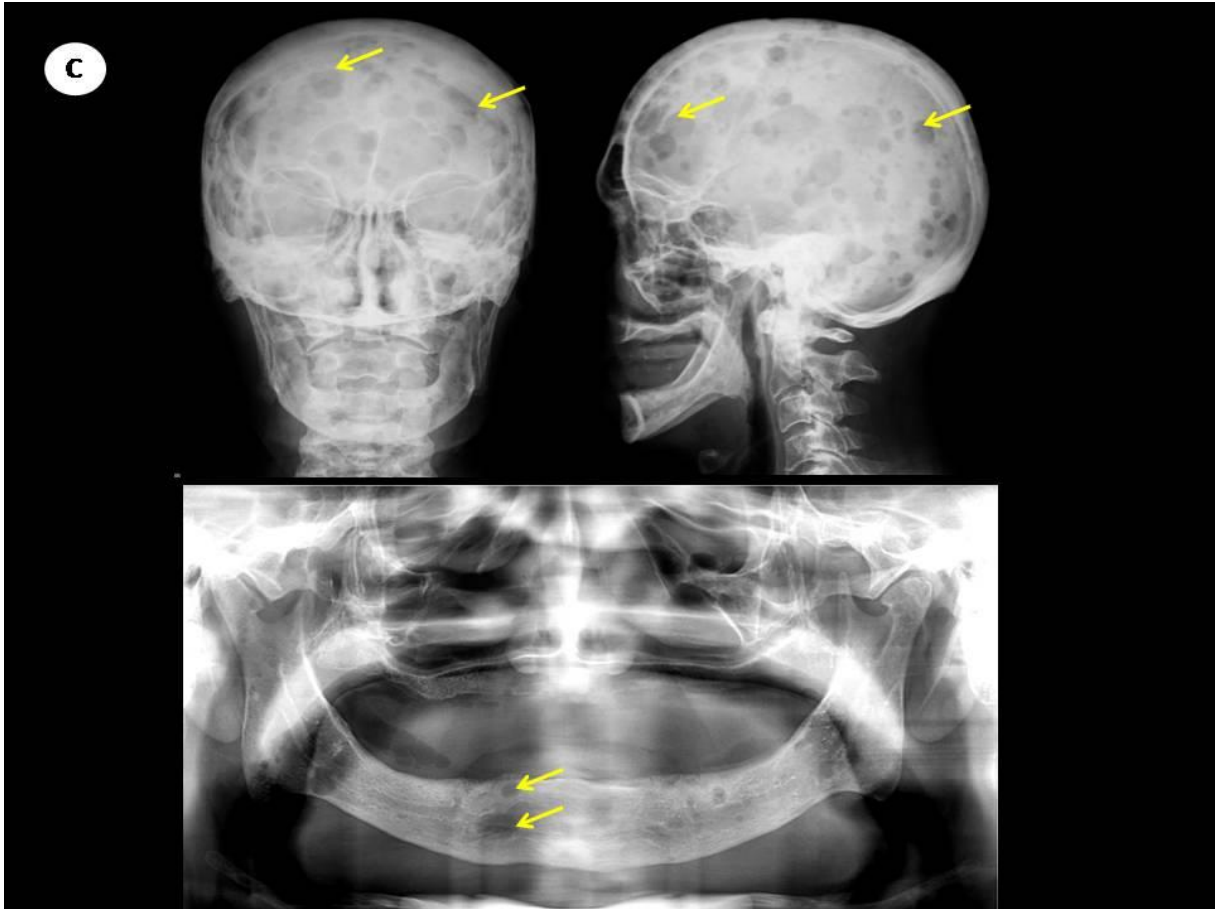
Radiographic patterns of MM in craniofacial bones. A. Panoramic radiographic evaluation showing punched-out lesions (arrows) affecting maxilla and mandible and a large osteolytic image (arrowhead) affecting the left ramus of the mandible. Frontal and lateral skull radiographs of the same patient presenting multiple punched-out lesions (arrow). B. Panoramic radiographic evaluation showing punched-out lesions (arrows) affecting maxilla and mandible. Frontal and lateral skull radiographs of the same patient presenting multiple punched-out lesions (arrow). C. Panoramic radiographic evaluation showing punched-out lesions (arrows) affecting maxilla and mandible. Frontal and lateral skull radiographs of the same patient presenting multiple punched-out lesions (arrow).
